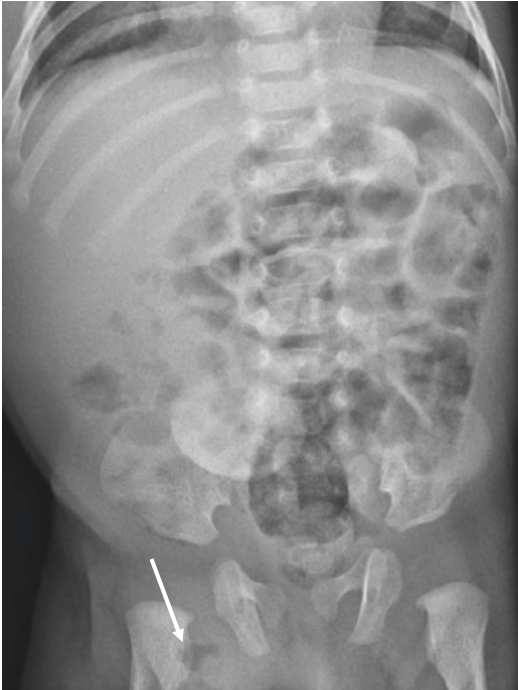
Complicated inguinal hernia in a 1-month-old boy with vomiting and swelling in the inguinal region. Supine abdominal radiograph shows gas in the right inguinal region (*arrow*). There is only moderate dilatation of the small bowel
